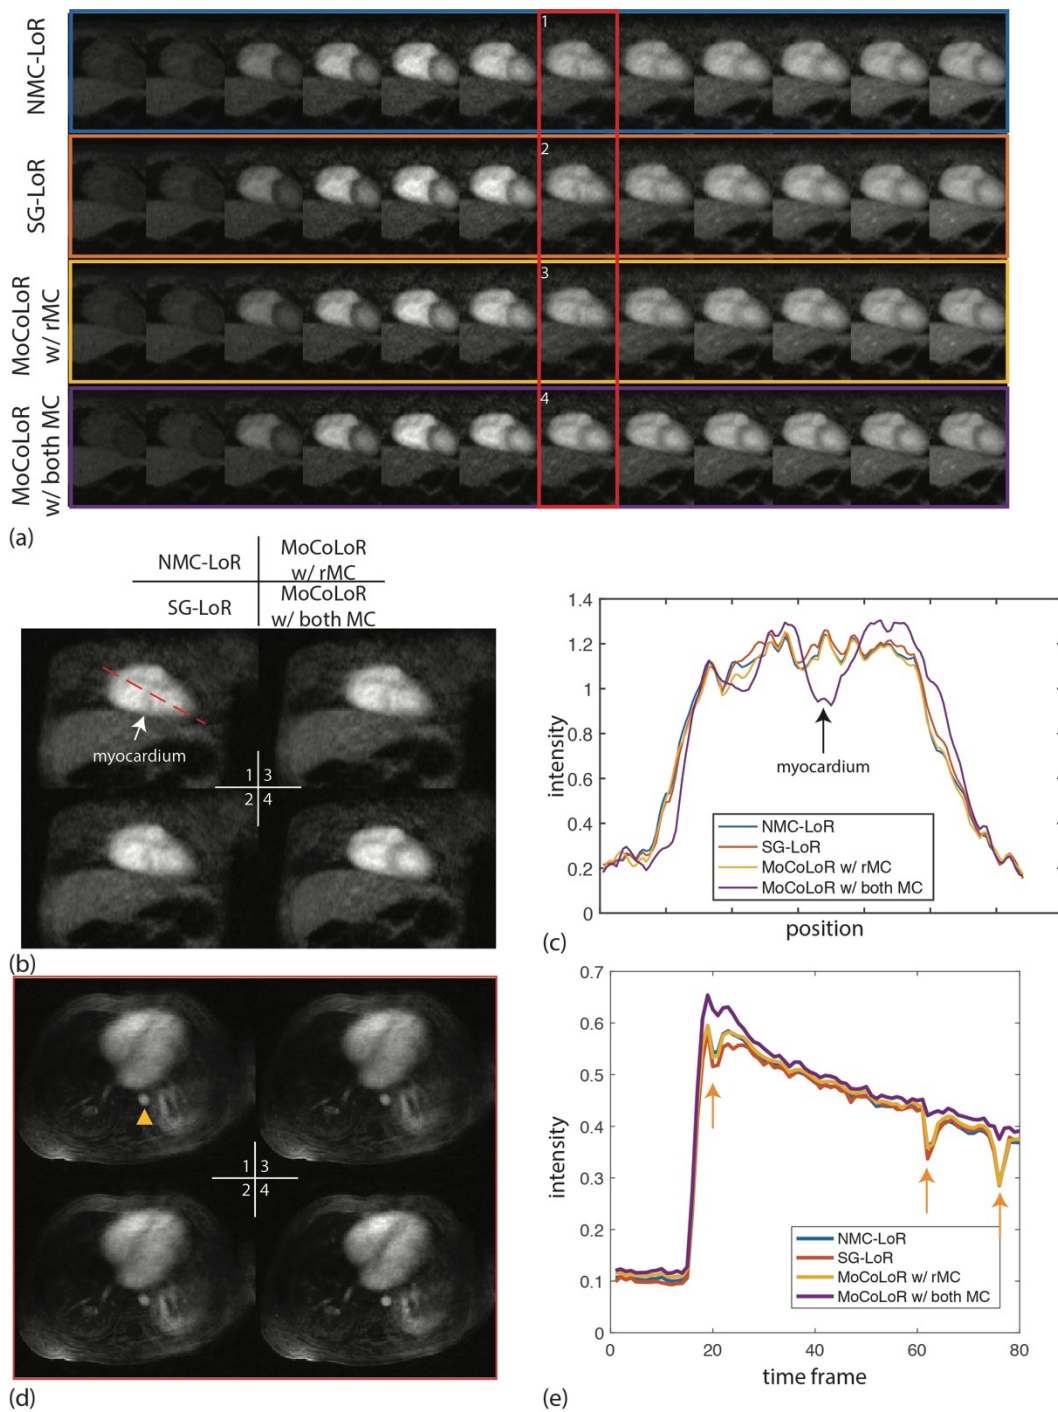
DCE MRI reconstruction results. DCE images reconstructed by 4 different reconstruction strategies are plotted in (a). Images framed by the red rectangle are shown in (b). Line profiles across the heart are plotted in (c). The axial plane images are shown in (d). Dynamic signals of thoracic aorta are plotted in (e), the signals corrupted by bulk motion are pointed out by orange arrows.
